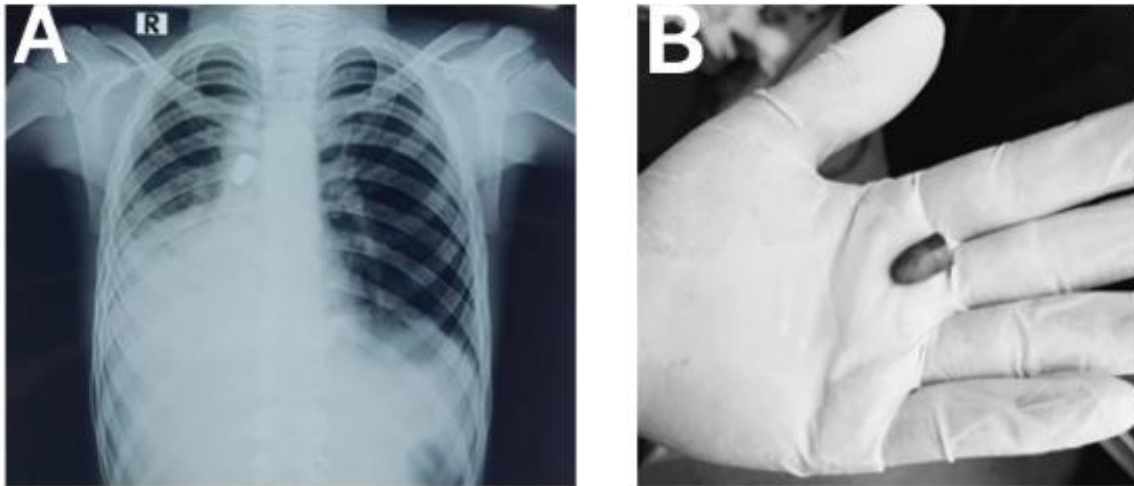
(A) X-ray Chest PA view showing a radio-opaque shadow consistent with a bullet lodged in the right main bronchus (B) Showing the retrieved bullet.
